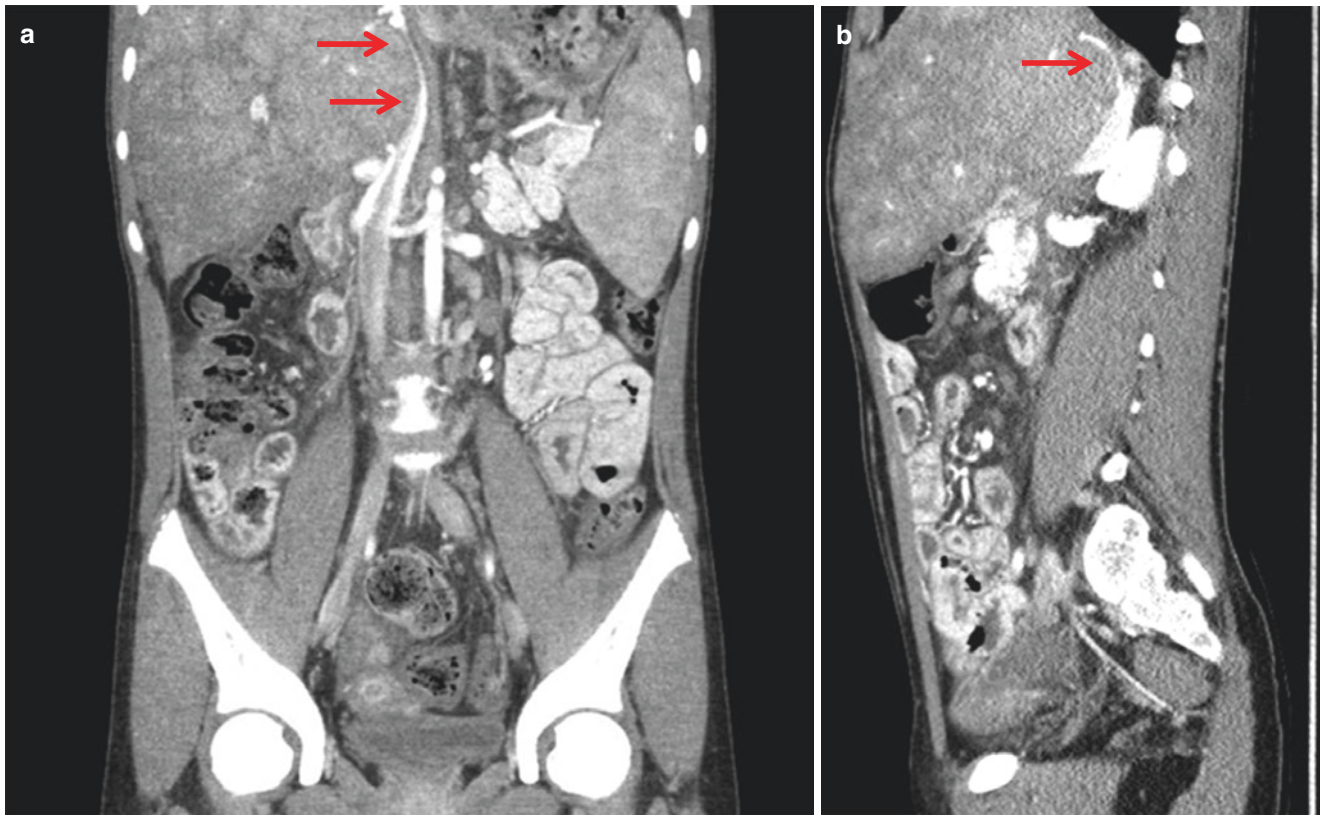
IVC narrowing. CT scan abdomen showing compression of IVC (arrows) coronal and lateral view
